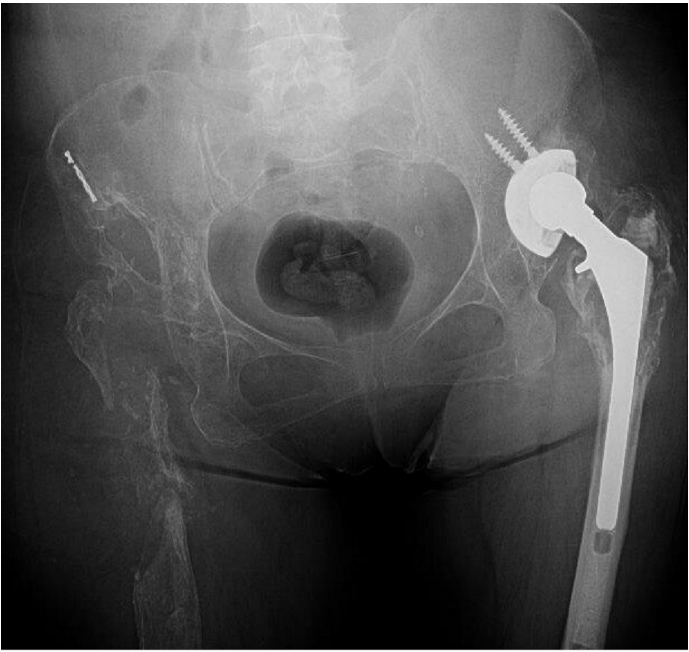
Radiograph of a patient treated with Girdlestone procedure because of persistent periprosthetic joint infection
